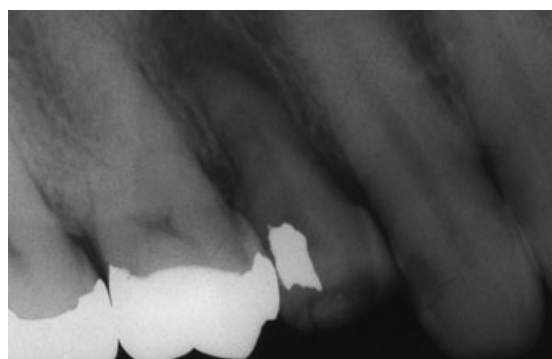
Radiograph immediately after transplantation.
